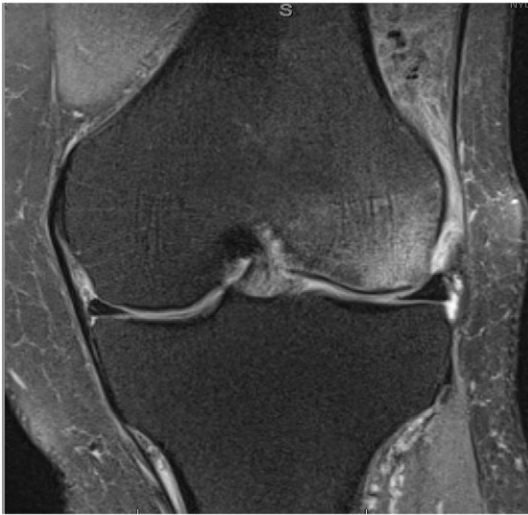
MRI of the left knee revealing marked bone marrow edema and focal subchondral fracture in the weight-bearing region of the lateral femoral condyle.
